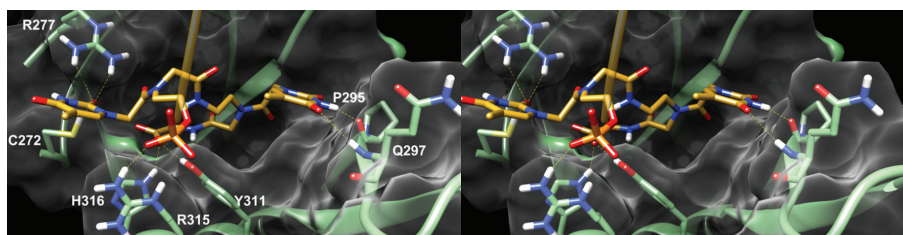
Stereoview of the predicted binding mode of the 3'-OH-PNA AS of siRNA 17 in the hAgo 2 X-ray structure. For clarity reasons, the PNA structure is depicted (yellow sticks) while the RNA backbone is shown as an orange transparent ribbon. The protein is depicted as green sticks (interacting residues) and ribbons and white transparent surface. H-bonds are indicated as yellow dashed lined.
